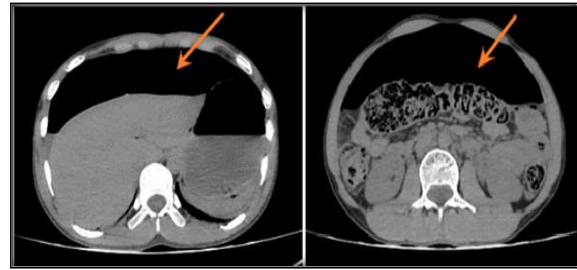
CT pain abdomen axial section showing massive pneumoperitoneum (arrow)
